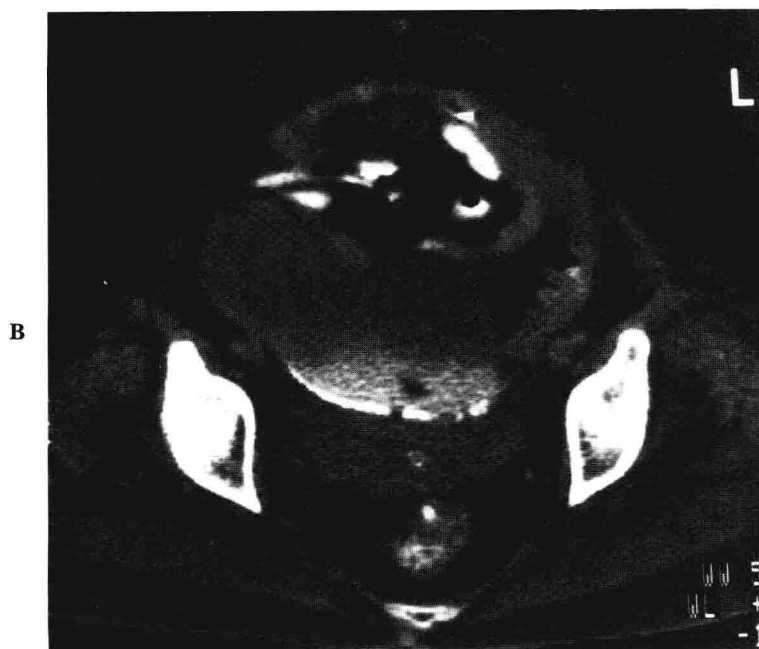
cont'd. B, CT scan of same patient approximately 30 minutes later shows increasing amounts of oral contrast medium collecting in the fluid, indicating communication with the bowel. At surgery a loop of ileum was perforated, communicating with a large pelvic abscess. Water-soluble contrast material was used in this case because of a history of fever in postoperative patients.
